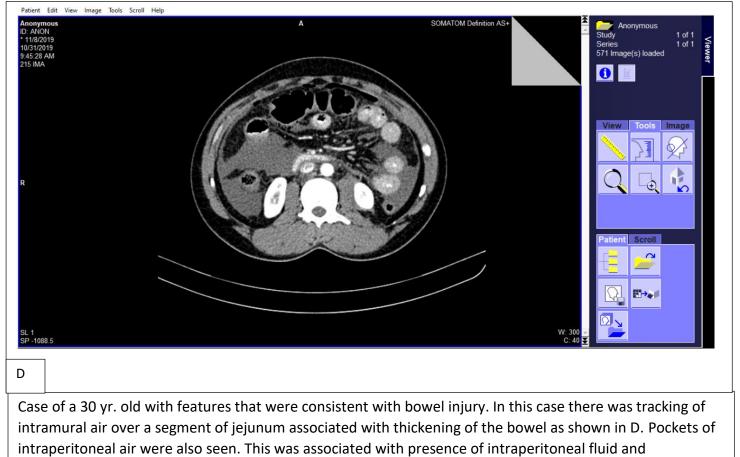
Serial CT scan images demonstrating bowel injury
